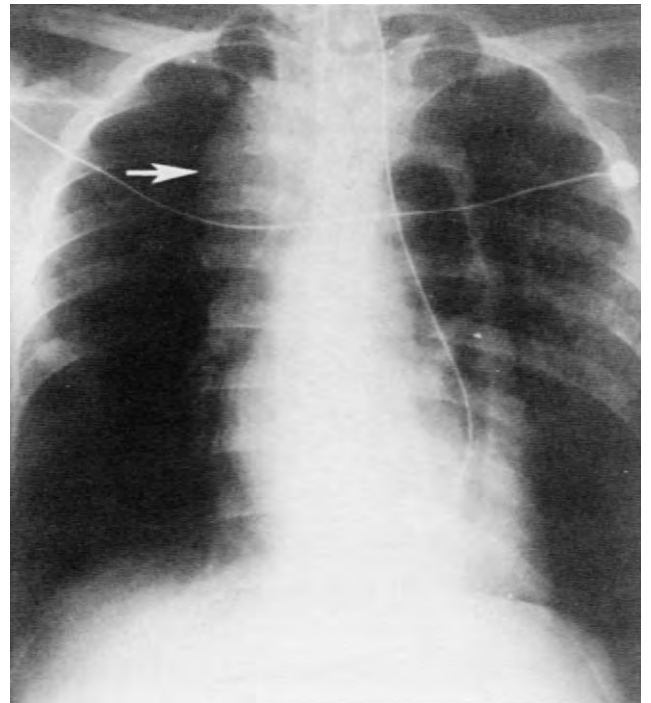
Posteroanterior chest roentgenogram in a 27-year-old man being evaluated for acute respiratory distress 2 years after undergoing substernal gastric bypass of the excluded thoracic esophagus for a caustic stricture. The patient had compression of the tracheobronchial tree by a huge posterior mediastinal mucocele (*arrow*) that had formed in the excluded esophagus. An endotracheal tube was required to relieve the airway obstruction. A nasogastric tube is seen in the retrosternally placed stomach. A right-sided thoracotomy and resection of the dilated esophagus were carried out.
